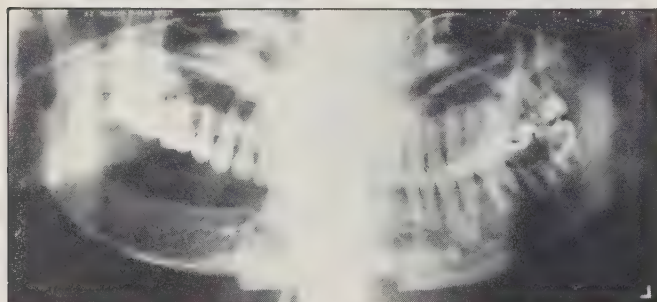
Two week post-surgical panoramic radiograph of the microvascular iliac crest graft replacing the right hemi-mandible. The inter-osseous wire loops provide initial stabilization. Comparing left to right, note that the graft is smaller, less calcified, and lacks a cortex.
